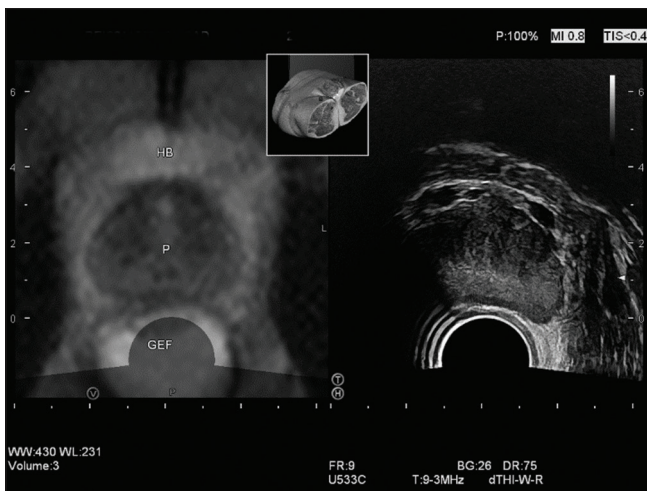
Fusion of pelvic imaging using magnetic resonance imaging and endorectal ultrasound. The prostate gland was displayed transversally, in contrast to magnetic resonance imaging, identical rectal filling was not possible; P: Prostate; HB: Urine bladder; RW: Rectal wall
